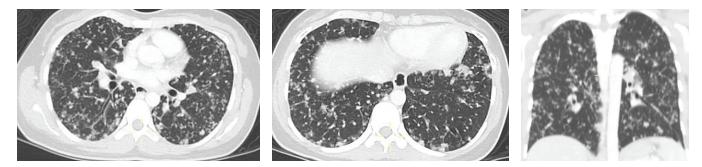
Axial and coronal contrast-enhanced CT of the chest lung window showing diffuse bilateral reticulonodular densities in centrilobular pattern.
